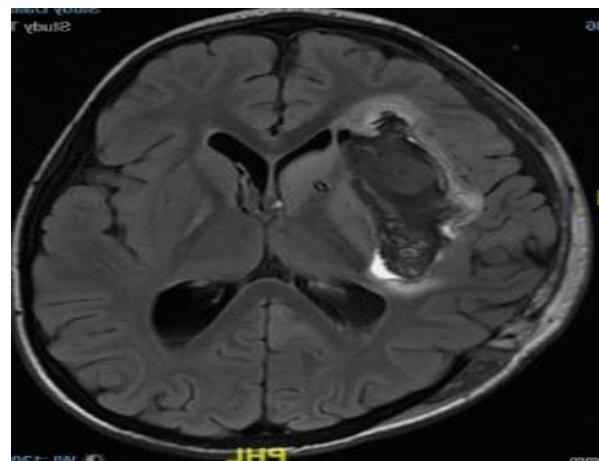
CT brain, axial view Showed large cerebral hemisphere acute parenchymal hemorrhage 6.6 x 3 cm with optimizing most of the frontal and the temporal lobe surrounded by vasogenic edema causing mass effect and midline shift, as well as interventricular hemorrhage bilateral extended to the fourth ventricle.
